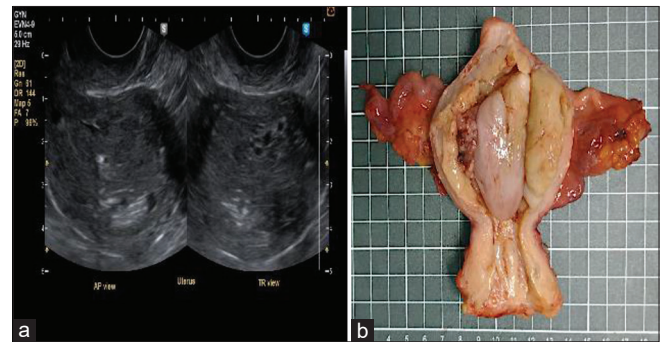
Ultrasound (a) appearance of a heterogeneous endometrial mass with irregular cystic areas. Gross (b) findings showed a polypoid mass bulging into the myometrium
